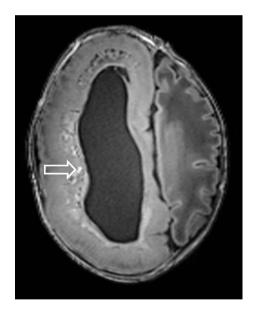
A neonate aborted at 31 weeks gestational age. Antenatal US showed abnormal brain development. Autopsy was refused by the parents. T1-W MRI shows asymmetrical development of the brain with overgrowth of the right side, in keeping with hemimegalencephaly. On the right side multiple focal hemorrhagic lesions are seen (arrow) (slice thickness: 1 mm, TR: 9, TE: 4,1)⁵⁸
